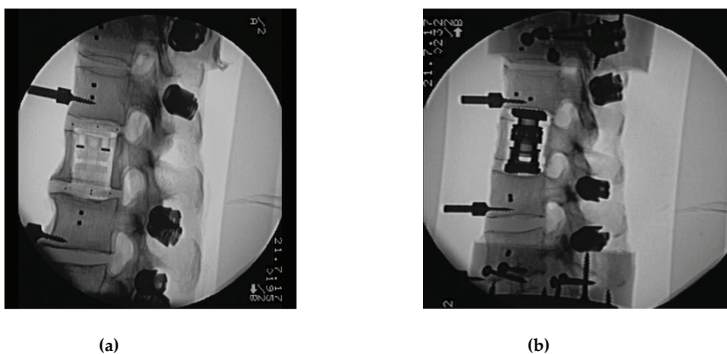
Lateral view native radiographs documenting correct positioning of the (a) prototype non-metallic, X-ray-translucent CF/PEEK expandable vertebral body replacement (VBR) and the expandable titanium VBR (b).
